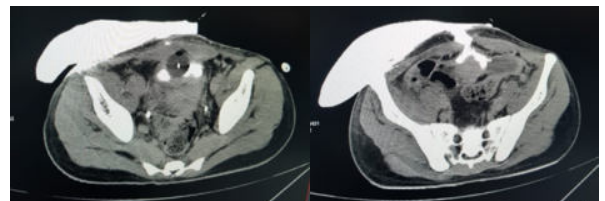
CT image showing Foley's bulb inside bladder (red arrow) and extravasation of contrast through anterior abdomen wall into the urobag outside
